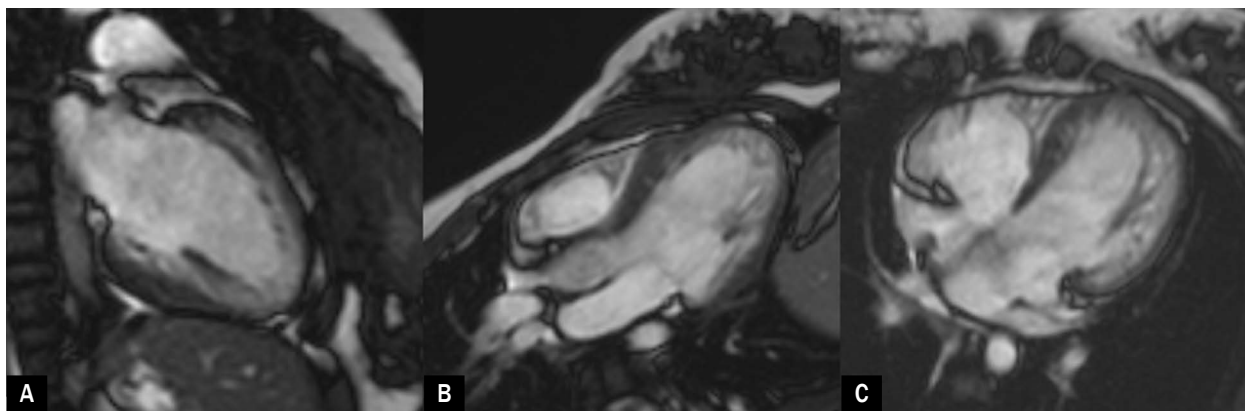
An magnetic resonance image showing increased trabeculation; A. 2-chamber view; B. 3-chamber view; C. 4-chamber view
